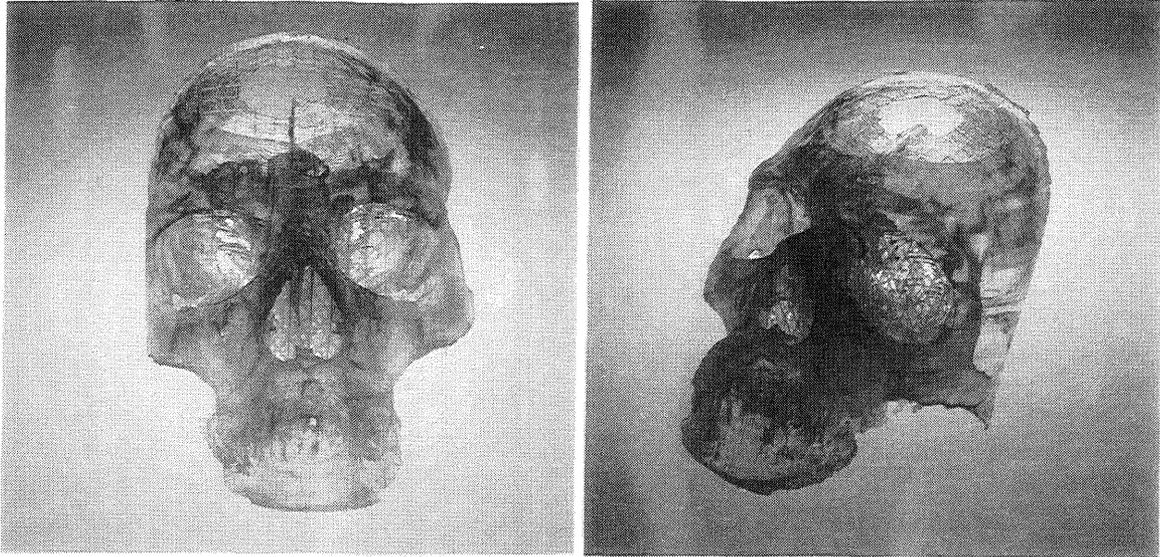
Stereolithography model based on CT scan.
